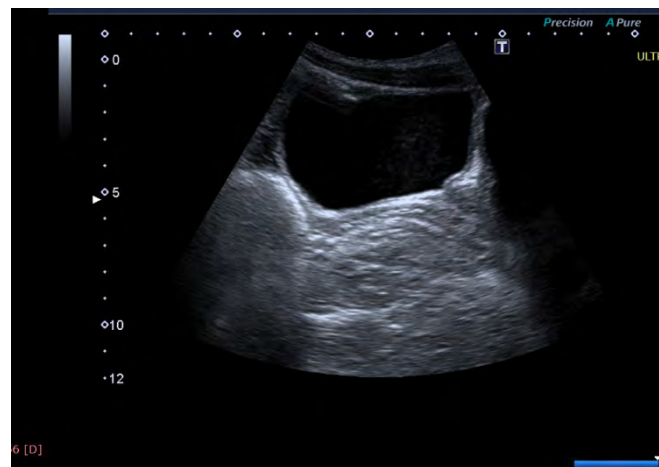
Pelvic ultrasound: Absence of a uterus and ovaries.
